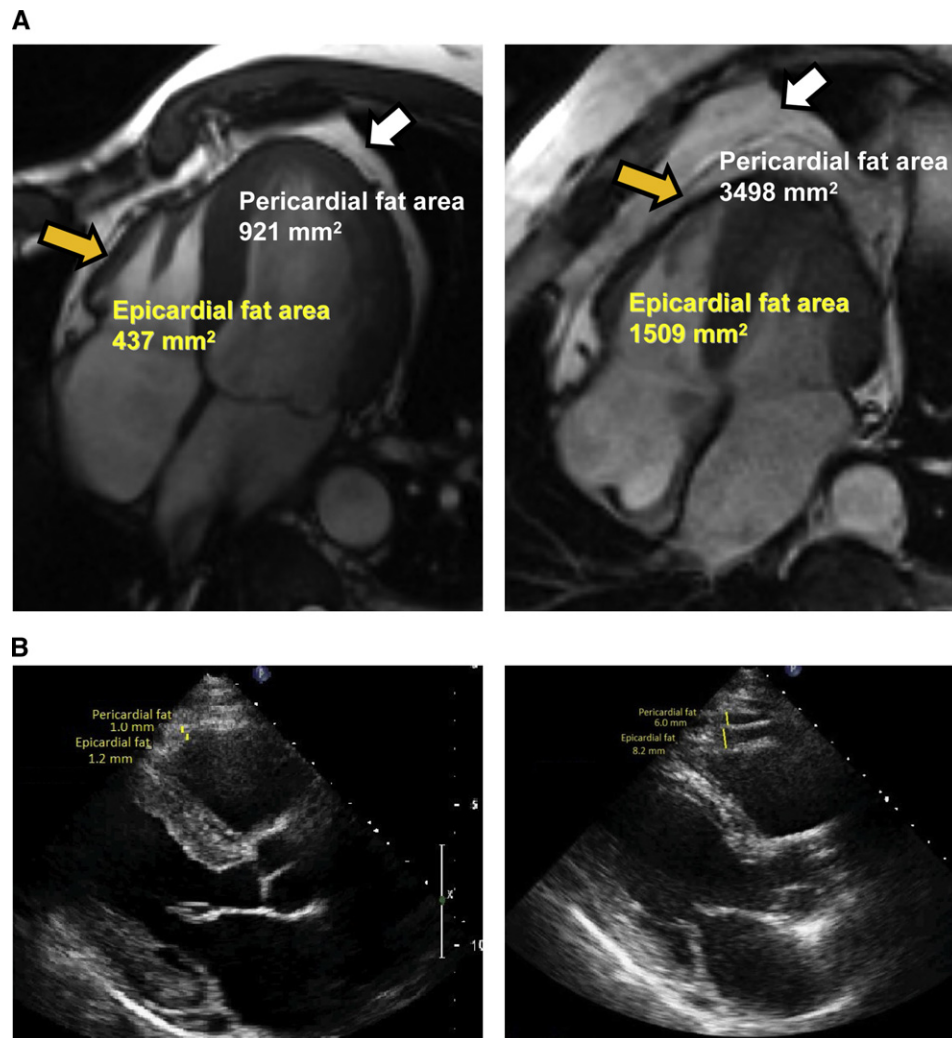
(Top) Four-chamber view of the heart of a subject with low total cardiac fat (*left*) and a subject with high total cardiac fat (*right*). (Bottom) Transthoracic long-axis view of the heart of a subject with cardiac (intra-abdominal and PERI) fat (*left*) and cardiac fat (*right*).
